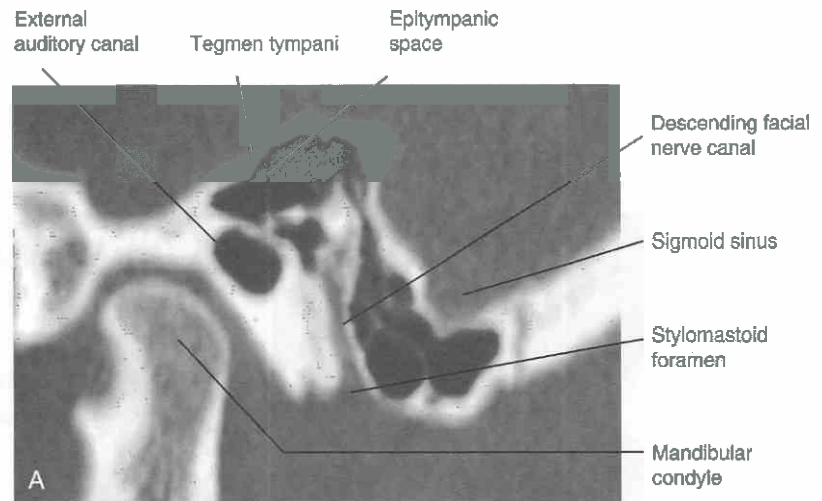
Sagittal views, normal anatomy. *A*, Sagittal CT reconstruction through the descending facial nerve canal and stylomastoid foramen. The mastoid air cells and sigmoid sinus lie just posterior to the facial nerve. The mandibular condyle, mandibular fossa, external auditory canal, and epitympanic space are visible. *B*, Sagittal MRI section. *C*, CT surface reconstruction of the lateral skull and mandible centered over the external auditory canal.
